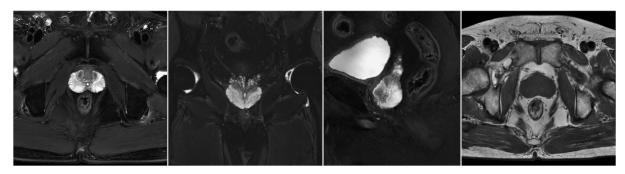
High-resolution prostate imaging with 5.0T MRI, T2-weighted fatsuppressed FSE images in axial, coronal, and sagittal planes, and axial T1-weighted FSE $(0.5 \times 0.5 \times 3 \text{ mm}^3)$; the fine internal structure and zonal anatomy of the prostate gland are clearly visualized.
